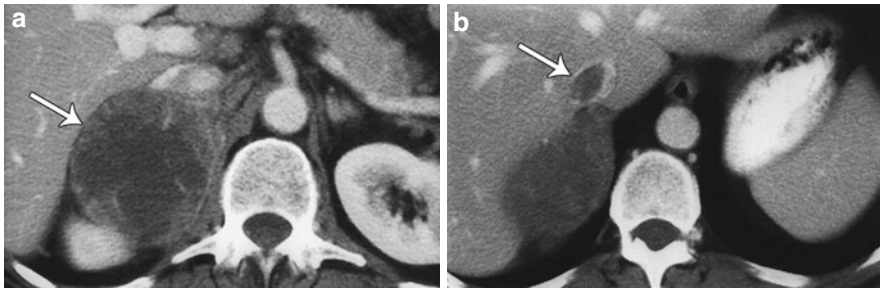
Adrenal cortical carcinoma. (a) Contrast-enhanced computed tomography (CT) examination shows 9-cm right adrenal mass. Irregular wall and low-density center indicate necrosis. (b) More cephalad image in same examination reveals tumor extension into inferior vena cava (*arrow*). (Reprinted with permission from [11])
